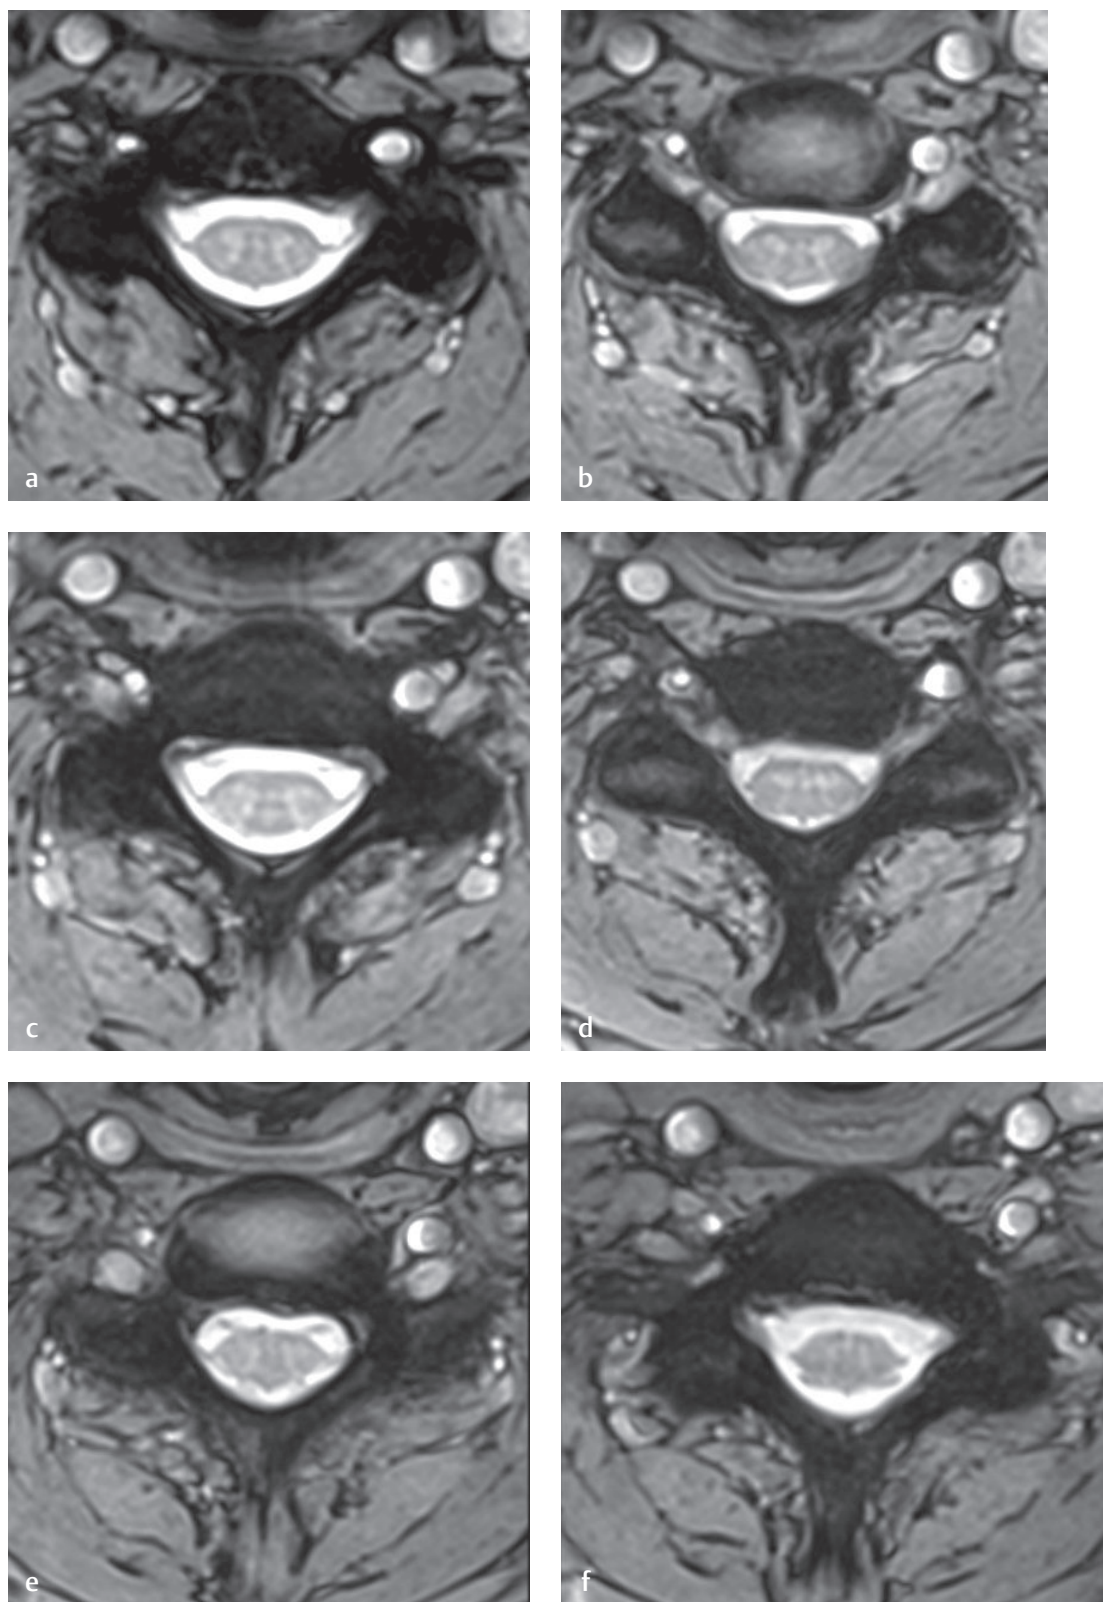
Sequential axial imaging of the cervical spine. These T2-weighted images should be viewed in order from (a) C6 to (f) T1.[†]
